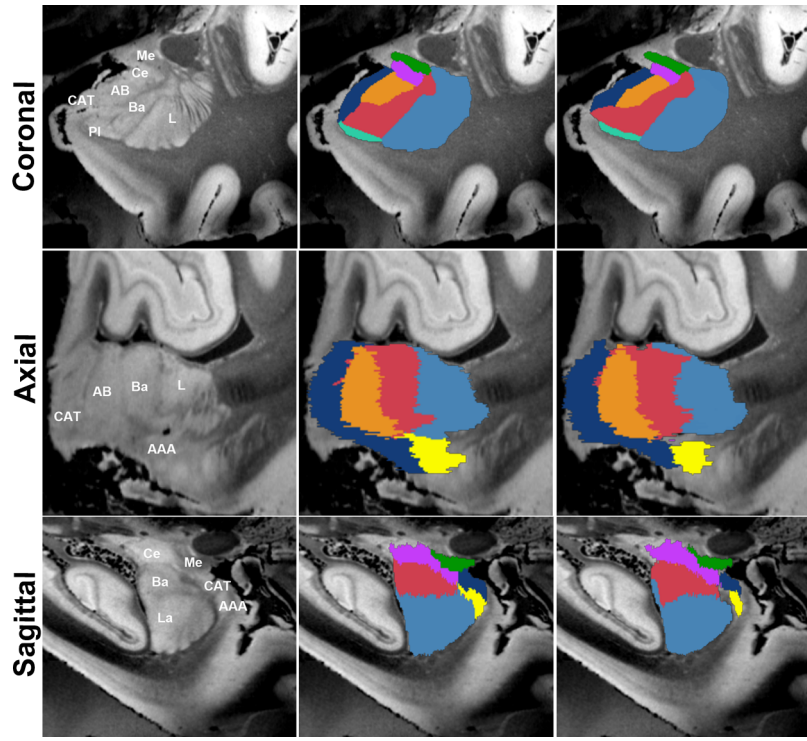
Inter-rater comparison of nucleus labels (case 1). Another example *ex vivo* case depicting the MRI contrast without any labels (left column) and with the manually-labeled nuclei produced by the two raters (middle and right columns). The location and spatial extent of the nuclei were similar between the two independent raters. Labels were based mainly on boundaries visible on coronal slices, but the two other orientations (axial and sagittal) were especially useful for checking boundaries of nuclei that were elongated in those orientations such as Co, CAT, Ce, and Me nuclei.
